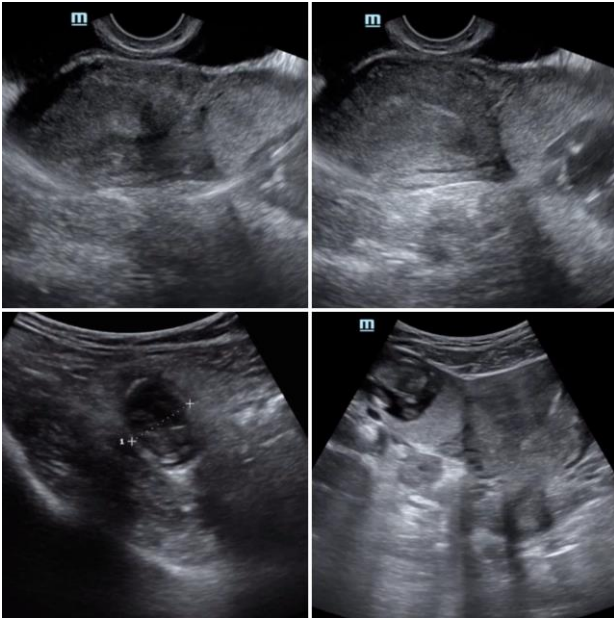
Preoperative Ultrasonographic Image of the Case at 13 weeks 1 day among the Cases Diagnosed with Cornual Pregnancy
